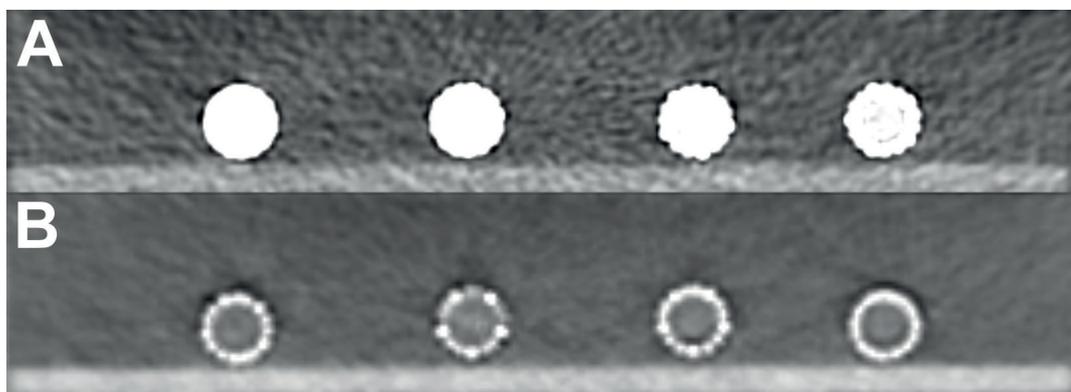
In vitro study using a set of stents filled with a solution of contrast medium. Stent-related artefacts in conventional polychromatic computed tomography angiography (CTA) (A) are much stronger than in dual-energy CTA reconstructed at 140 keV (B)
